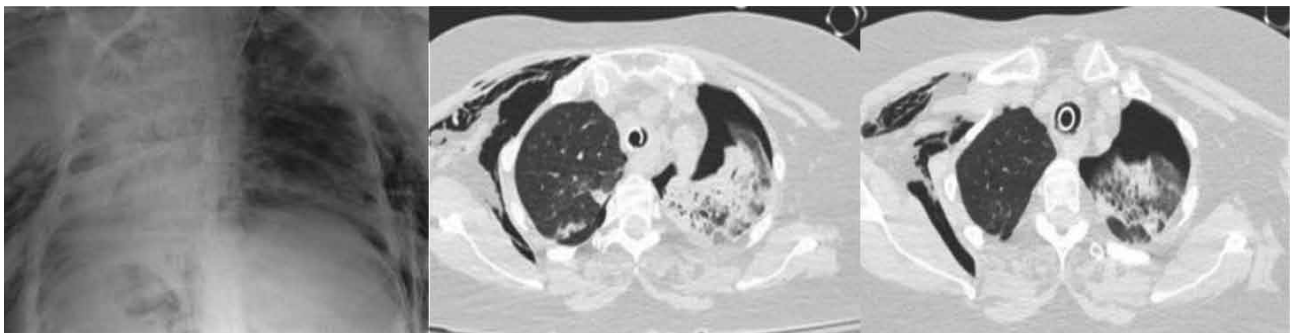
Barotrauma due to mechanical ventilation. CXR and CT demonstrated pneumothorax, and extensive subcutaneous emphysema.
